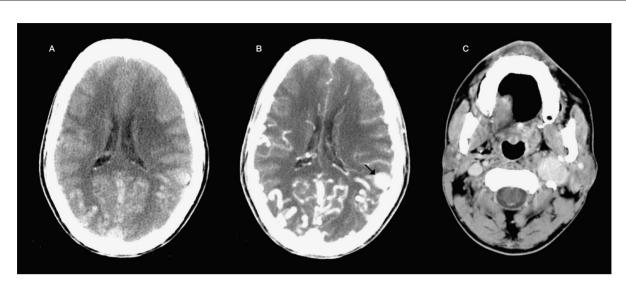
Plain (A) and contrast enhanced (B) CT scans at the level of the body of the lateral ventricles revealed multiple tortuous vessels - some of which showed venous ectasia (arrow). Contrast enhanced CT scan at the level of the 2nd cervical vertebra (C) revealed gross dilatation of the left internal jugular vein and non-visualization of left internal carotid artery.
